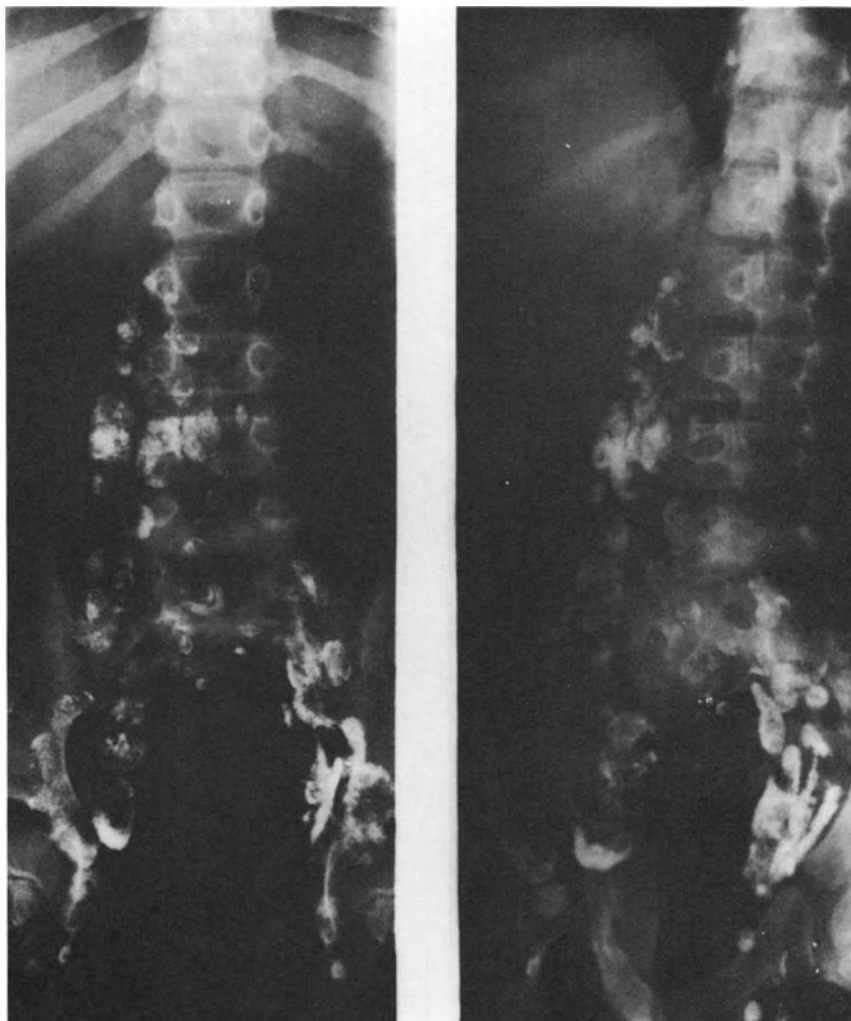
A lymphogram in an 8-year-old boy revealing diffusely abnormal lymph nodes in virtually all of the retroperitoneal lymph node chains. The abnormalities are of a sufficient size to also be visualized in an abdominal-pelvic CT scan as abnormally enlarged retroperitoneal adenopathy. However, the lymphogram reveals the abnormal lymph nodes to have filling defects and architectural changes characteristic of Hodgkin's disease.
